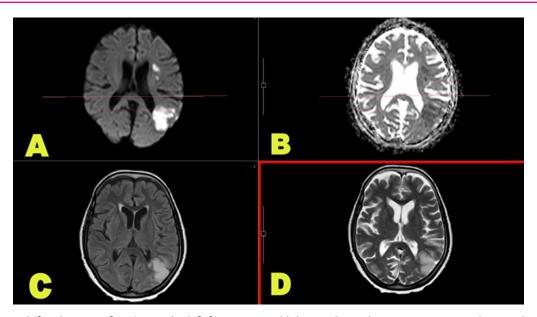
Multifocal acute infarction in the left frontoparietal lobe involving the MCA territory and watershed areas evidenced by areas of diffusion restriction (A) with corresponding low ADC signal (B) and T2 & FLAIR hyperintensities(C&D) in the lady with diffuse arachnoditis involving brain and spinal cord after 3 months of ATT treatment, presenting with confusion and severe agitation with slurred speech.
